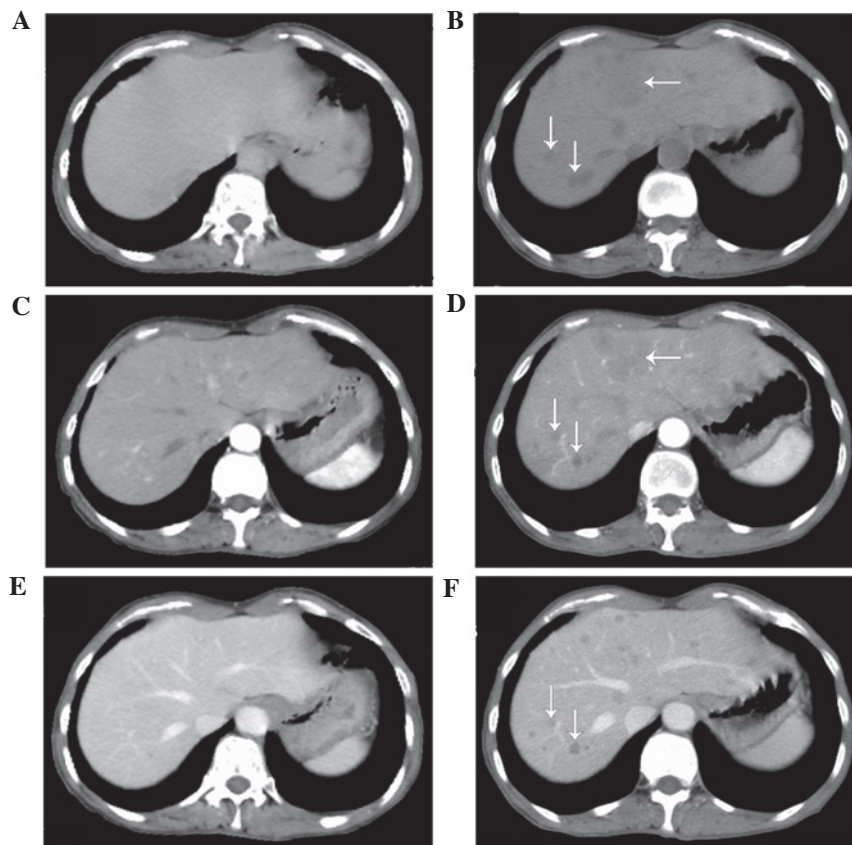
Hepatic computed tomography scans. Absence of hepatic metastasis prior to erlotinib treatment was observed on a (A) plain, (B) venous phase and (C) arterial phase scan (arrows). Presence of hepatic metastasis following 8 weeks of erlotinib treatment was observed on a (D) plain, (E) venous phase and (F) arterial phase scan (arrows).
